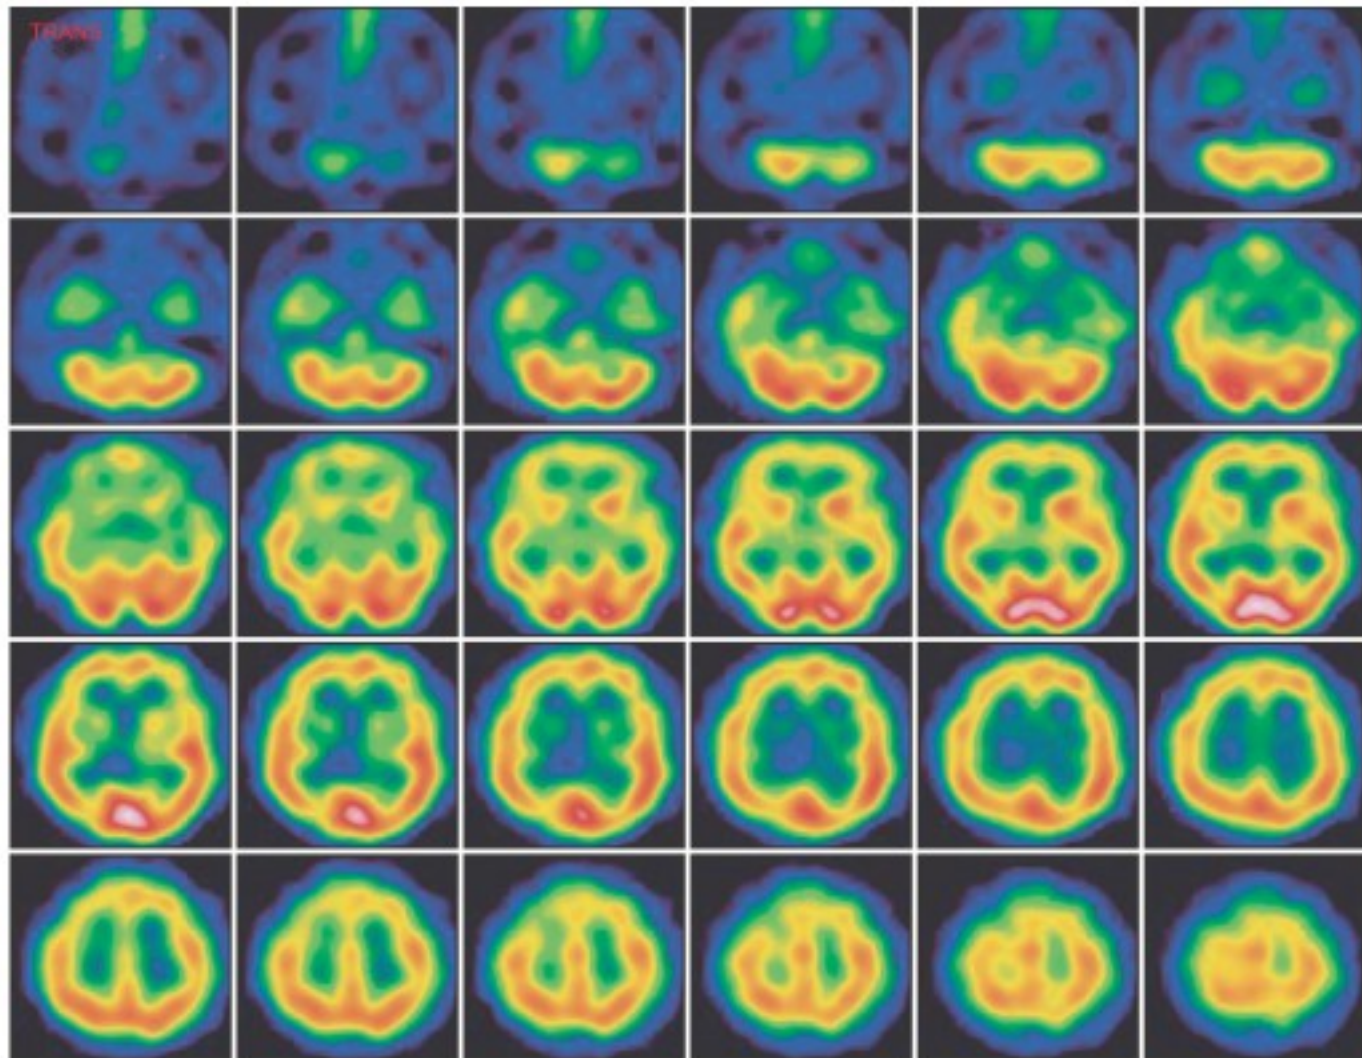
The brain single photon emission computed tomography scan shows mild diffuse hypoperfusion in the brain and especially in the right basal ganglia and left temporal region 1 month after cardiorespiratory resuscitation
